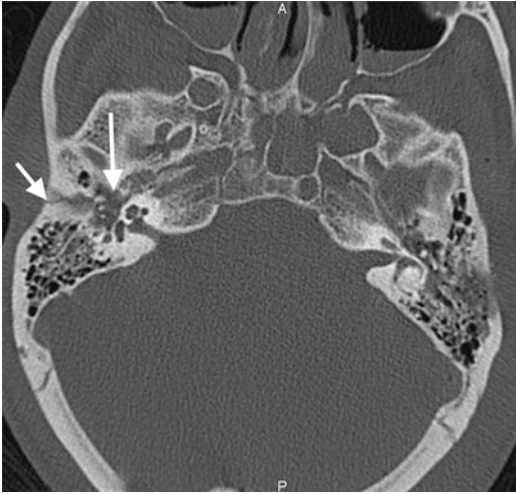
Hemotympanum. Axial head CT image demonstrates a linear fracture (short arrow) in the right temporal bone with hemotympanum (long arrow)
